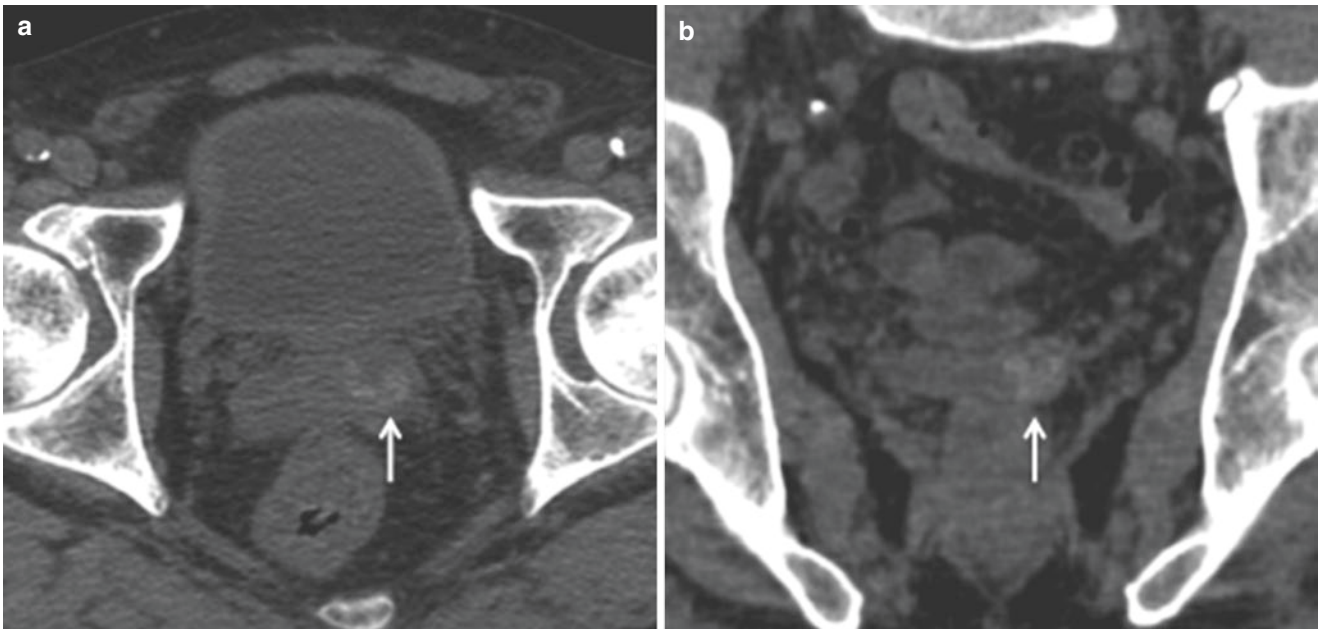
Calculi in a 31-year-old man with hematospermia. Axial (a) and coronal (b) CT sections show calculi in the left SV (arrows). Axial (c) and coronal (d) T2-weighted MR image shows again (arrows)
